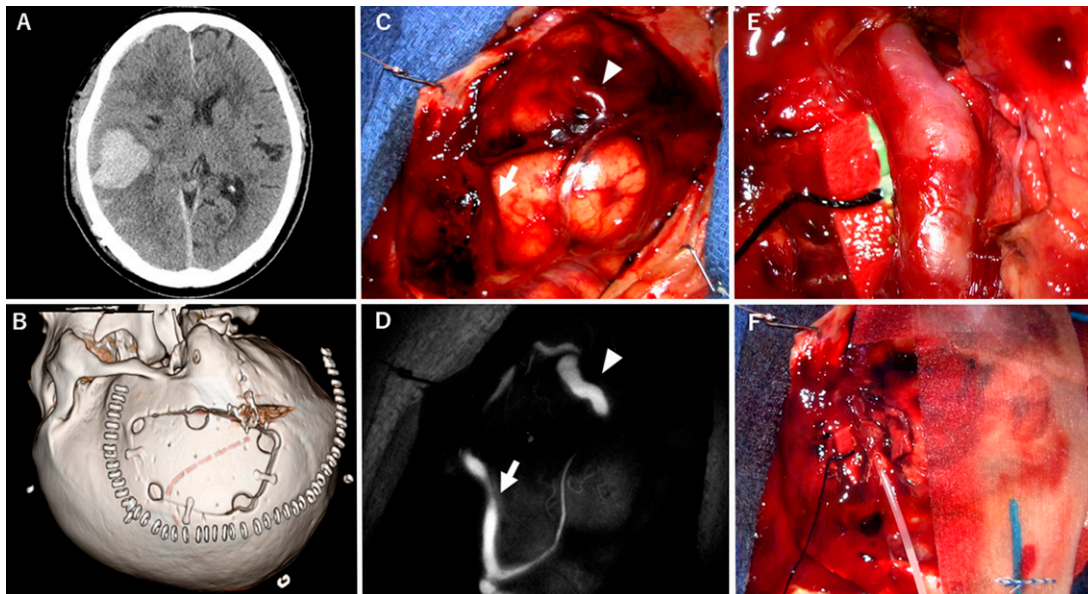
A: Preoperative brain CT showing hematoma enlargement with midline shift. Postoperative CT (B) showing temporoparietal craniotomy with U-shaped skin incision. Intraoperative photograph (C) and intra-arterial superselective indocyanine green video angiography (D) show the arterialized vein of Labbé (arrow) and posterior parietal vein (arrowhead) as seen on cerebral angiogram. The arterialized vein of Labbé was isolated for direct puncture (E). An 18-gauge needle was placed into the vein of Labbé, and 5-0 silken thread was tied (F).
